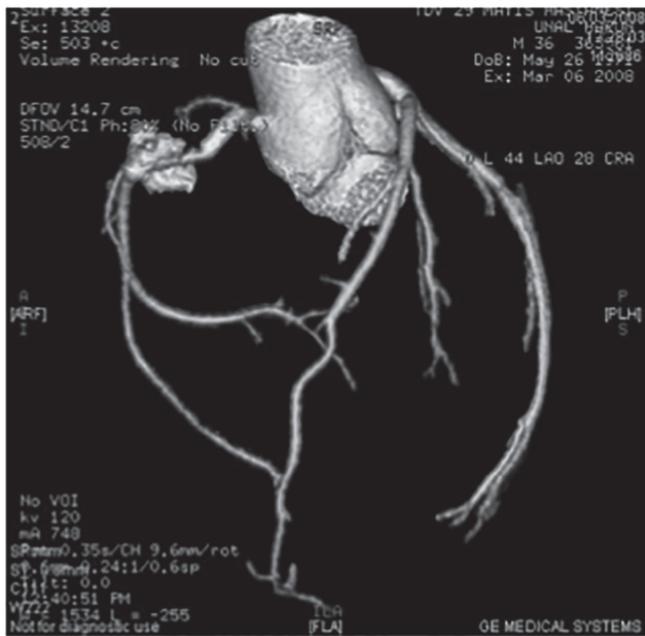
Coronary artery pseudoaneurysm demonstrated on right coronary CT angiography.
